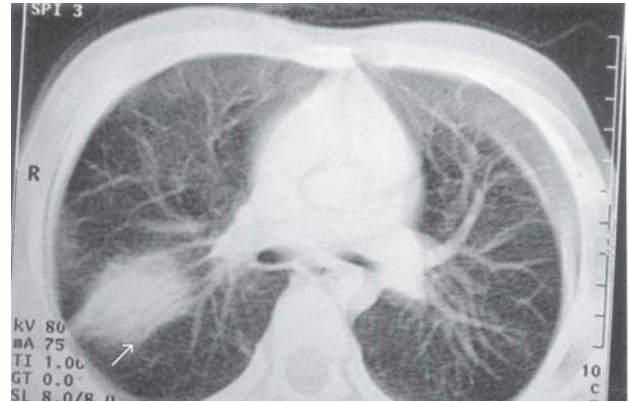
Computed tomography demonstrates a focal area of homogenous consolidation (arrow) in the right upper lobe. Note the presence of air-bronchogram within the consolidation.
